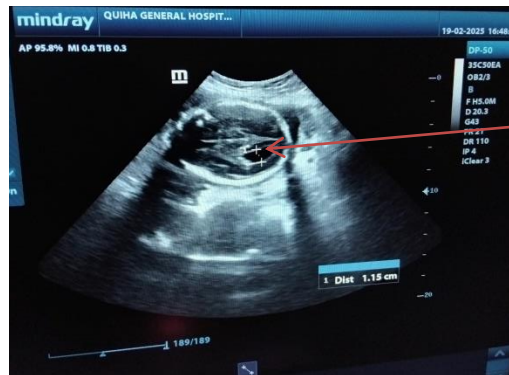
Ultrasonographically detected ventricular defects of fetus in 30 years old multi gravida pregnant woman at 29 weeks of gestation in Quiha general hospital, 2025.
